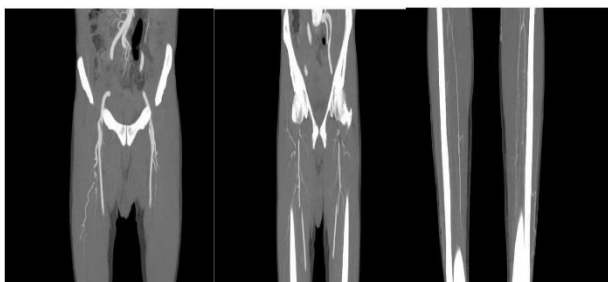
MIP images of a CT angiogram showing normal femoral and anterior tibial.
